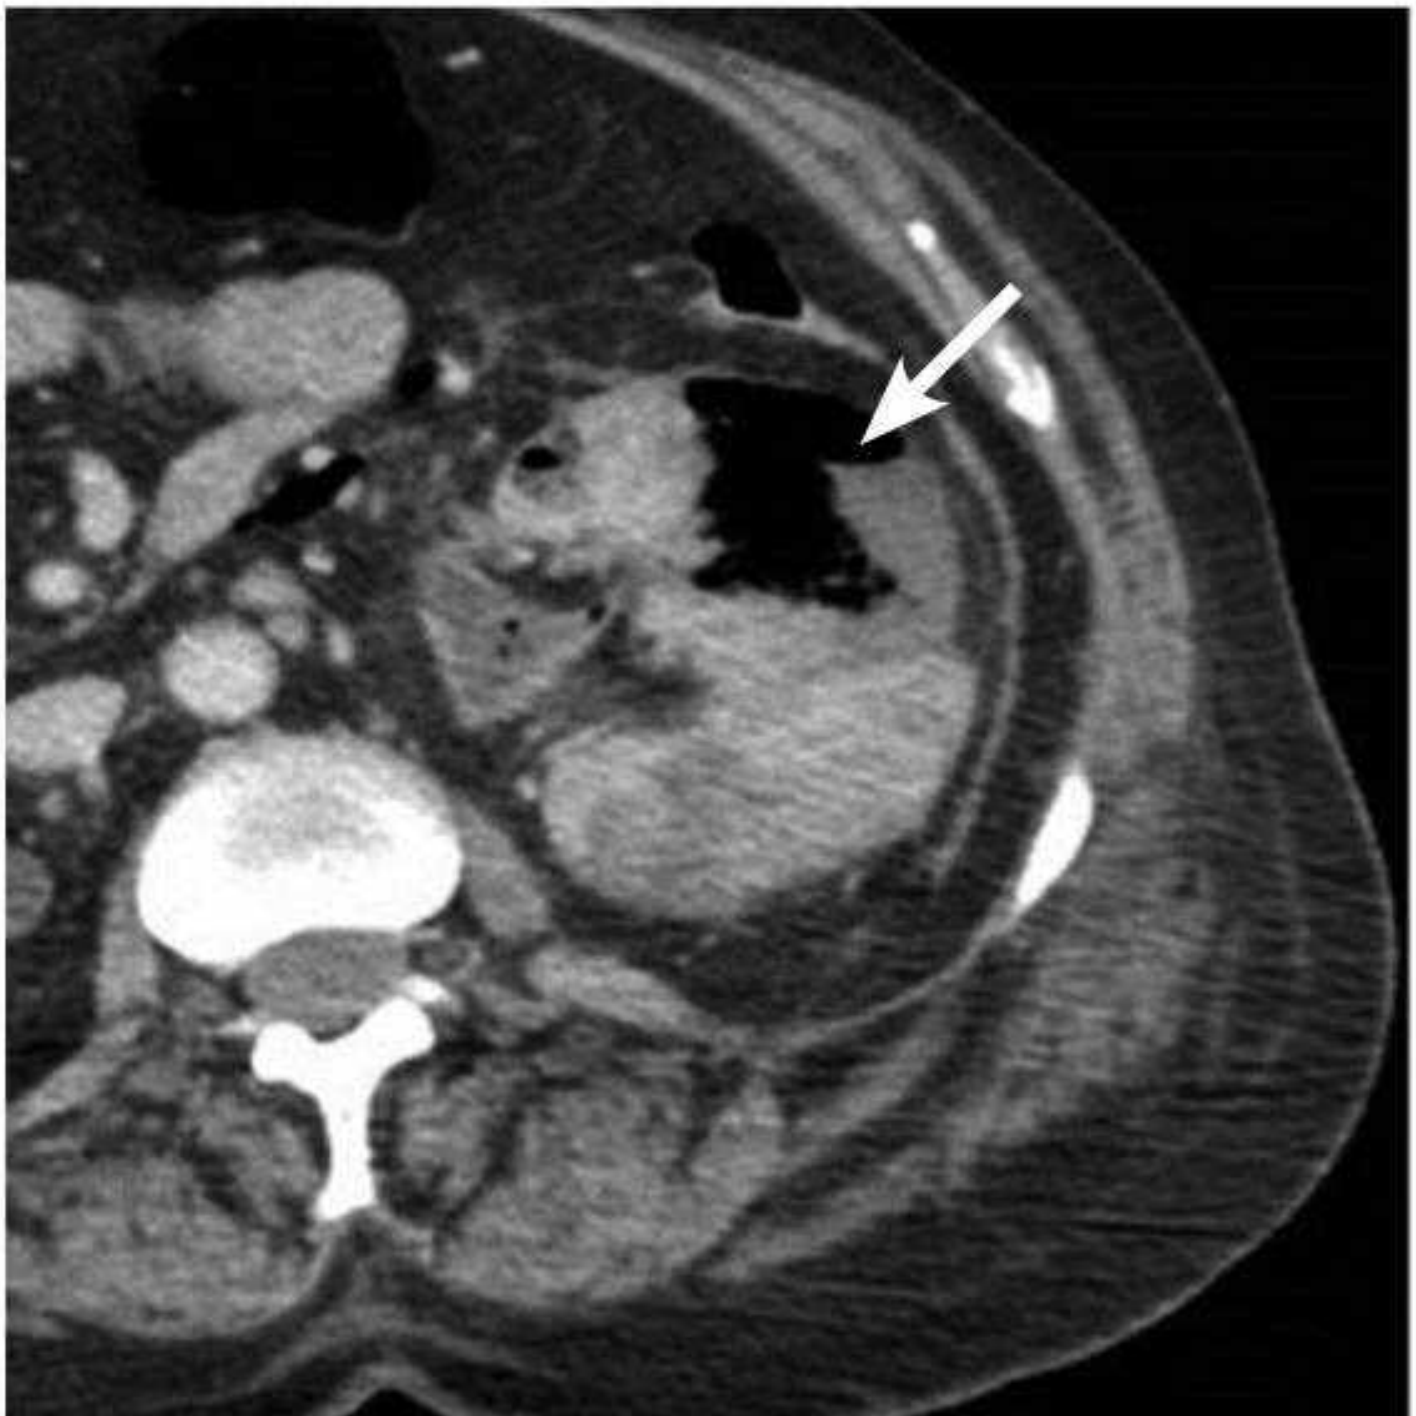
Axial portal phase computed tomography image of the left kidney showing emphysematous pyelonephritis with a thick enhancing renal pelvis containing gas along with a cortical gas-containing abscess (arrow).
